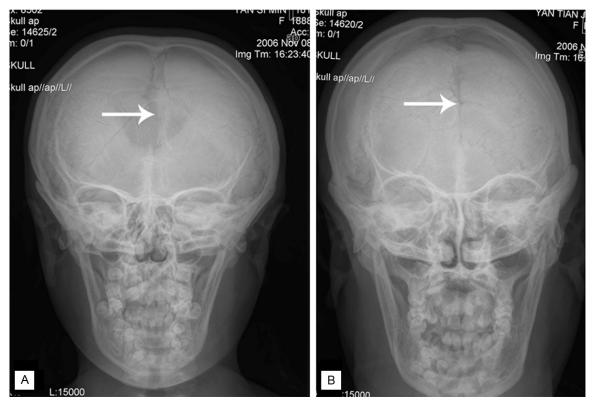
Orthophoria cephalometric radiographs: delayed closure of interparietal suture and fontanels in both the proband (A) and her mother (B).
